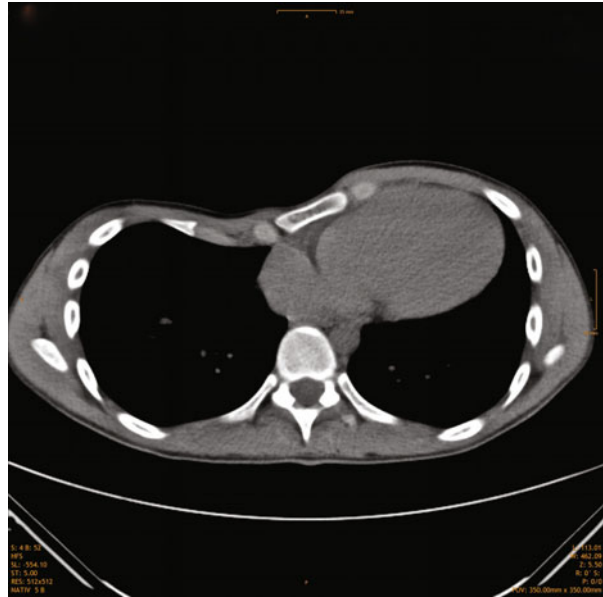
CT scan demonstrating cardiac compression and displacement, as well as pulmonary compression
